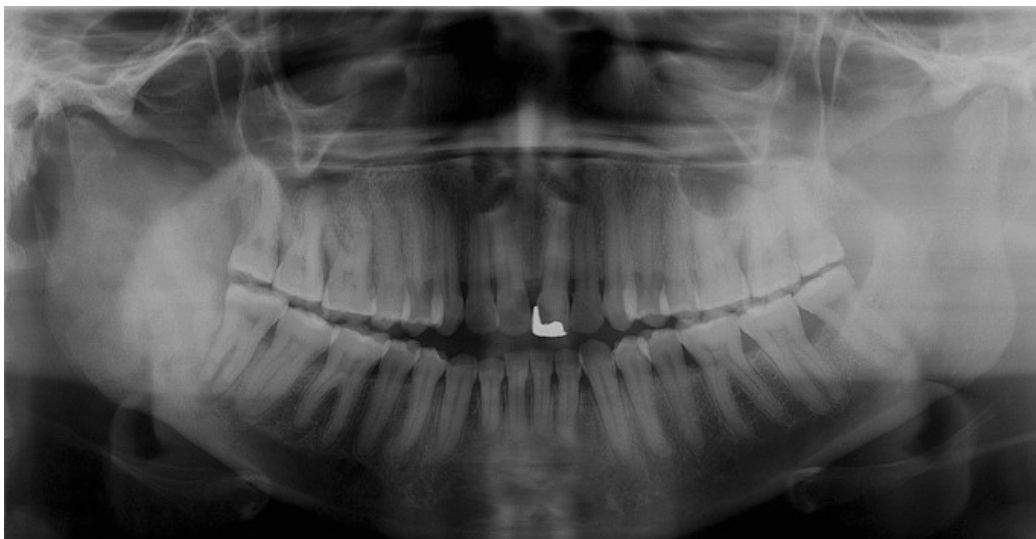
Case 11: Panoramic radiograph showing a poorly demarcated radiopaque lesion that resulted in significant expansion of the right mandibular ramus, sigmoid notch and coronoid process. The borders of the lesion blended into the surrounding bone.
